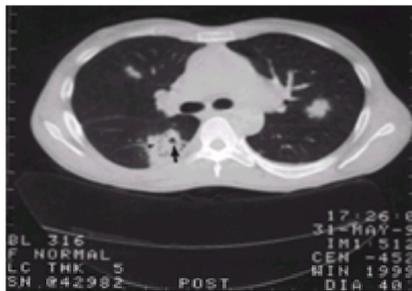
Chest CT reveals three poorly defined nodular infiltrates. In one of the nodular opacities, air bronchograms (*black arrowhead*) and cavitation (*black arrow*) are visible. The differential diagnosis is broad and includes a diverse clinical conditions such as non-Hodgkins lymphoma, bronchoalveolar cell carcinoma, and Wegner's granulomatosis. With an appropriate clinical history (e.g., a patient with fever and a new systolic murmur), the differential diagnosis is narrowed to septic emboli.
